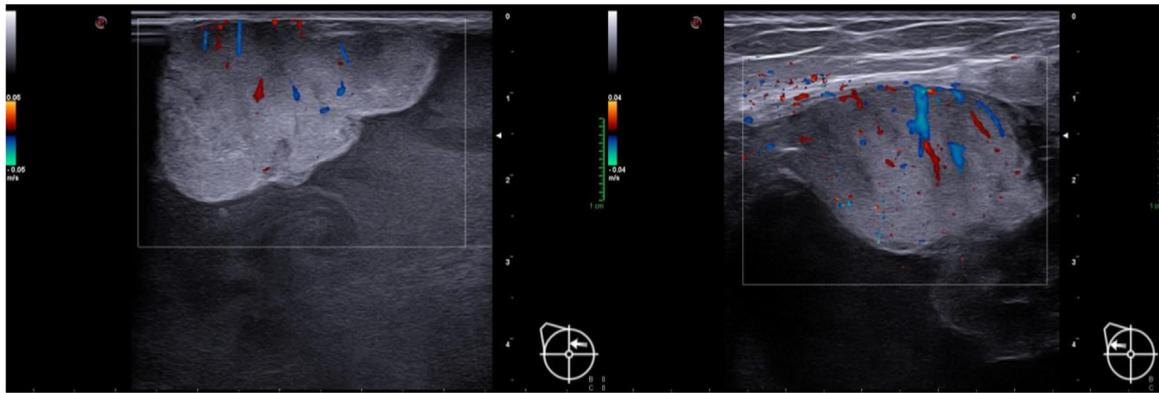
Solid component projecting into cystic component. Color-doppler module displays its rich vascularization.
